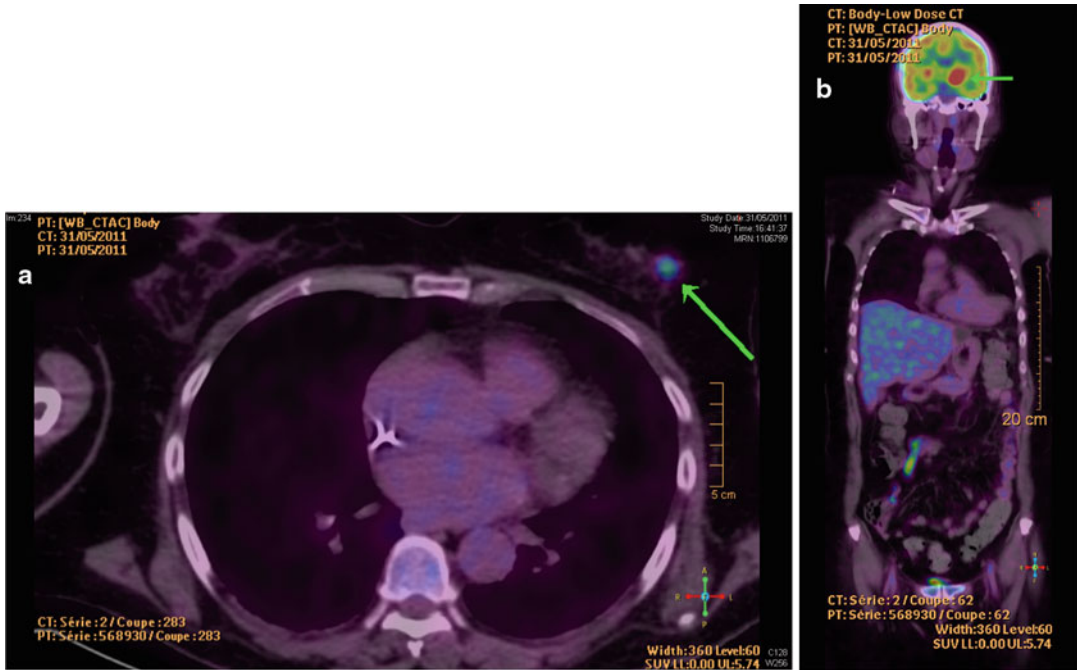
PET-CT at staging of a diffuse large B-Cell lymphoma revealed by a brain tumor. A 64-year-old woman presented with confusion, aphasia and a right hemiplegia. Brain CT-scan and MRI showed a left paraventricular lesion. Stereotactic biopsy proved the presence of a Diffuse Large B-Cell Lymphoma (DLBCL). PET-CT revealed a breast lesion (a) and confirmed 18-FDG uptake in the brain tumor (b). The biopsy of the breast mass
